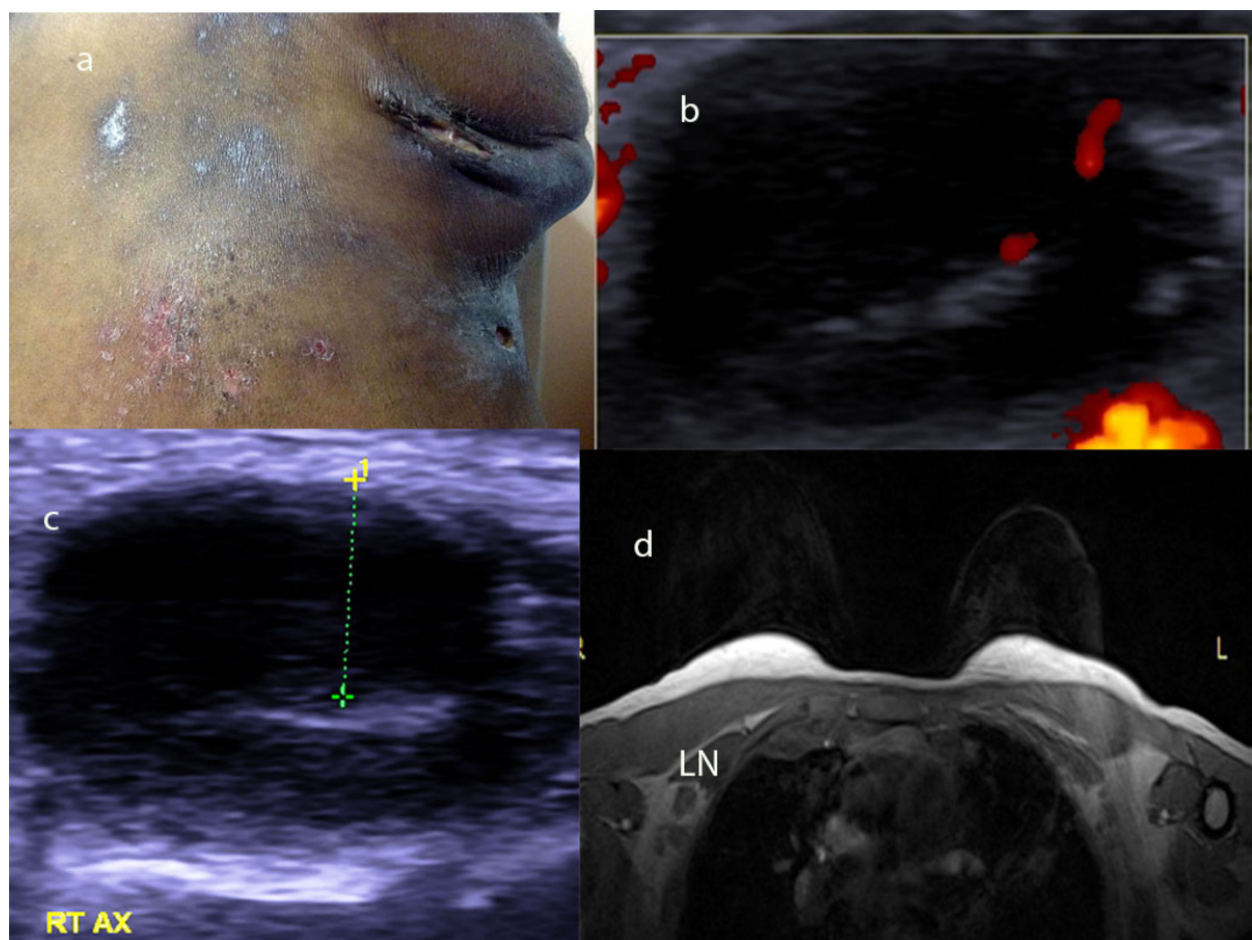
Tuberculous lymphadenitis. A. Left axilla enlarged nodes discharging onto skin sinuses. B. Ultrasound Doppler, hilum vessel and thick cortex seen. C. Ultrasound shows node with thick 7mm cortex (callipers). D. Breast MRI T1 post contrast axial image. Right axillary nodes (LN) have peripheral rim enhancement and central low signal (PRECLO).
